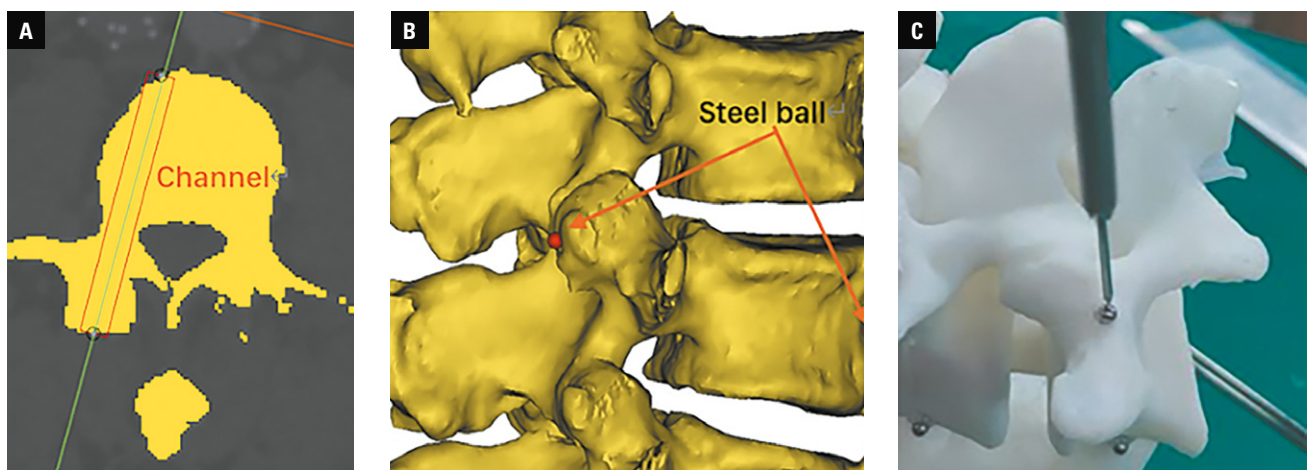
Precision test procedure. The channel indicates as pedicle screw was drawn on computed tomography (CT) scan imaging (A). Two ends of the channel: the foci of the channel and the facet, and the channel and the anterior edge of vertebral body, were marked (B). We made a 3-dimensional printing model according to the CT data and placed the steel balls on it. A joint-type 3-dimensional coordinate measuring machine was used to measure the straight-line distance from the steel balls to the central axis of the gauge (C).
